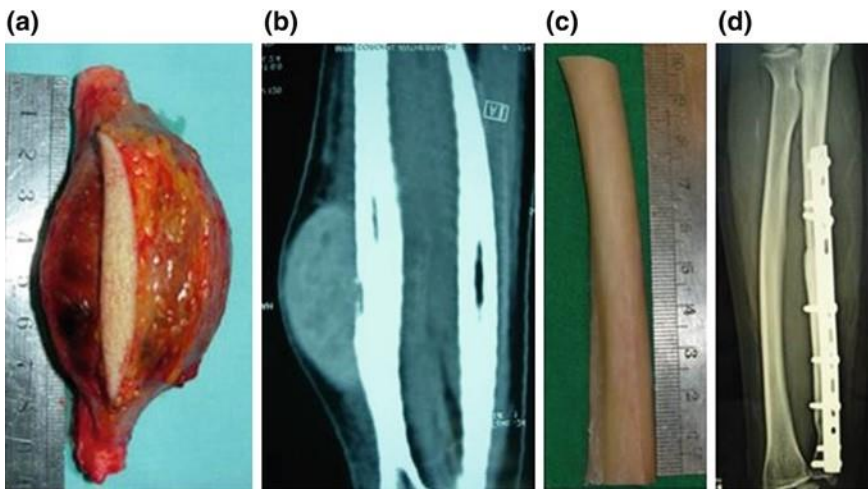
a Malignant soft tissue tumor with ulna bone infiltration, b tumor after bone resection, c intercalary bone allograft (10 cm), d X-ray after ulna bone reconstruction (Courtesy of Dr. Soetomo General Hospital, Surabaya)
